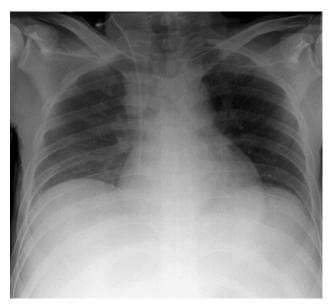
The supine chest radiograph at the emergency room.
